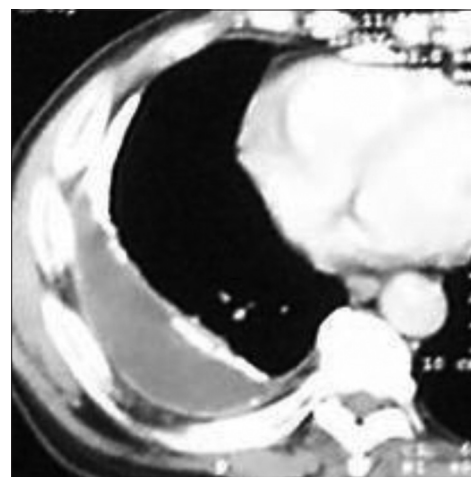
The CT cut of the thorax at the lower lung field (mediastinal window) showing thickening of the pleura and calcification both at the parietal and the visceral surfaces. This patient did not respond to oral doxycycline given for slightly over six months
